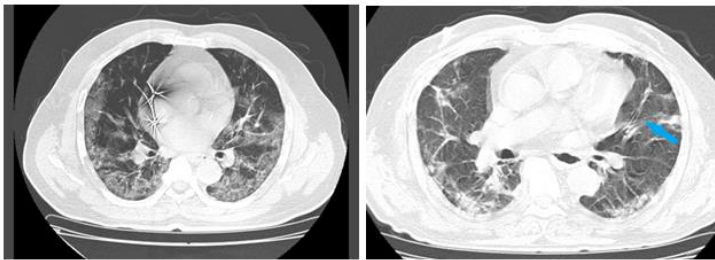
Axial HRCT image of the lung of a 61 yr old male patient showing interlobar septal thickening (blue arrow) along with bilateral pleural effusion.
